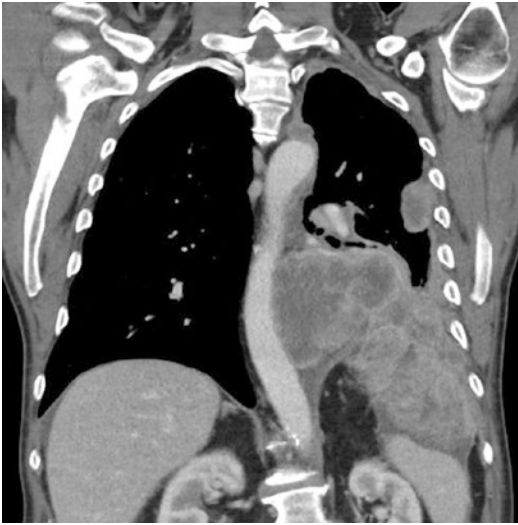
Extensive left-sided disease with clear destruction of, and extension through, the left hemidiaphragm displacing the spleen inferiorly (arrow) on this coronal CT section
